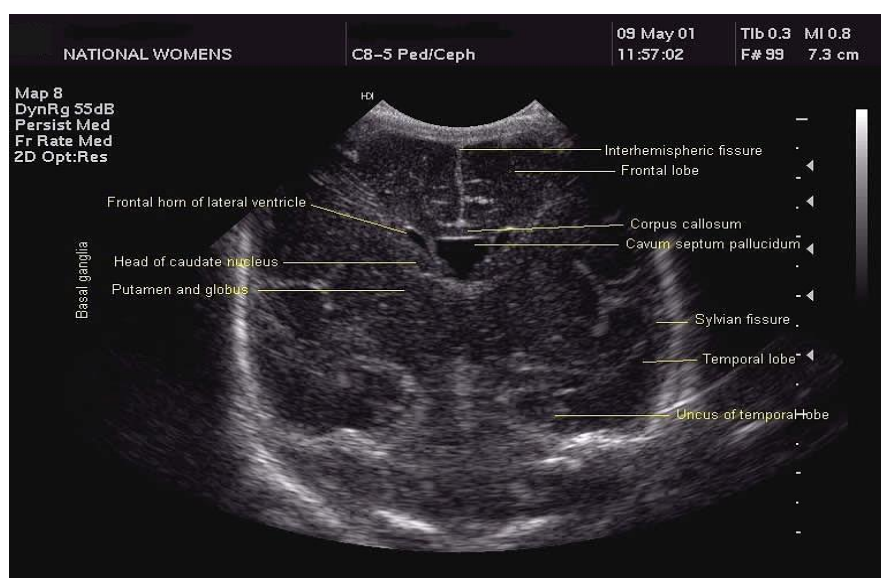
Ultrasound of the brain.
